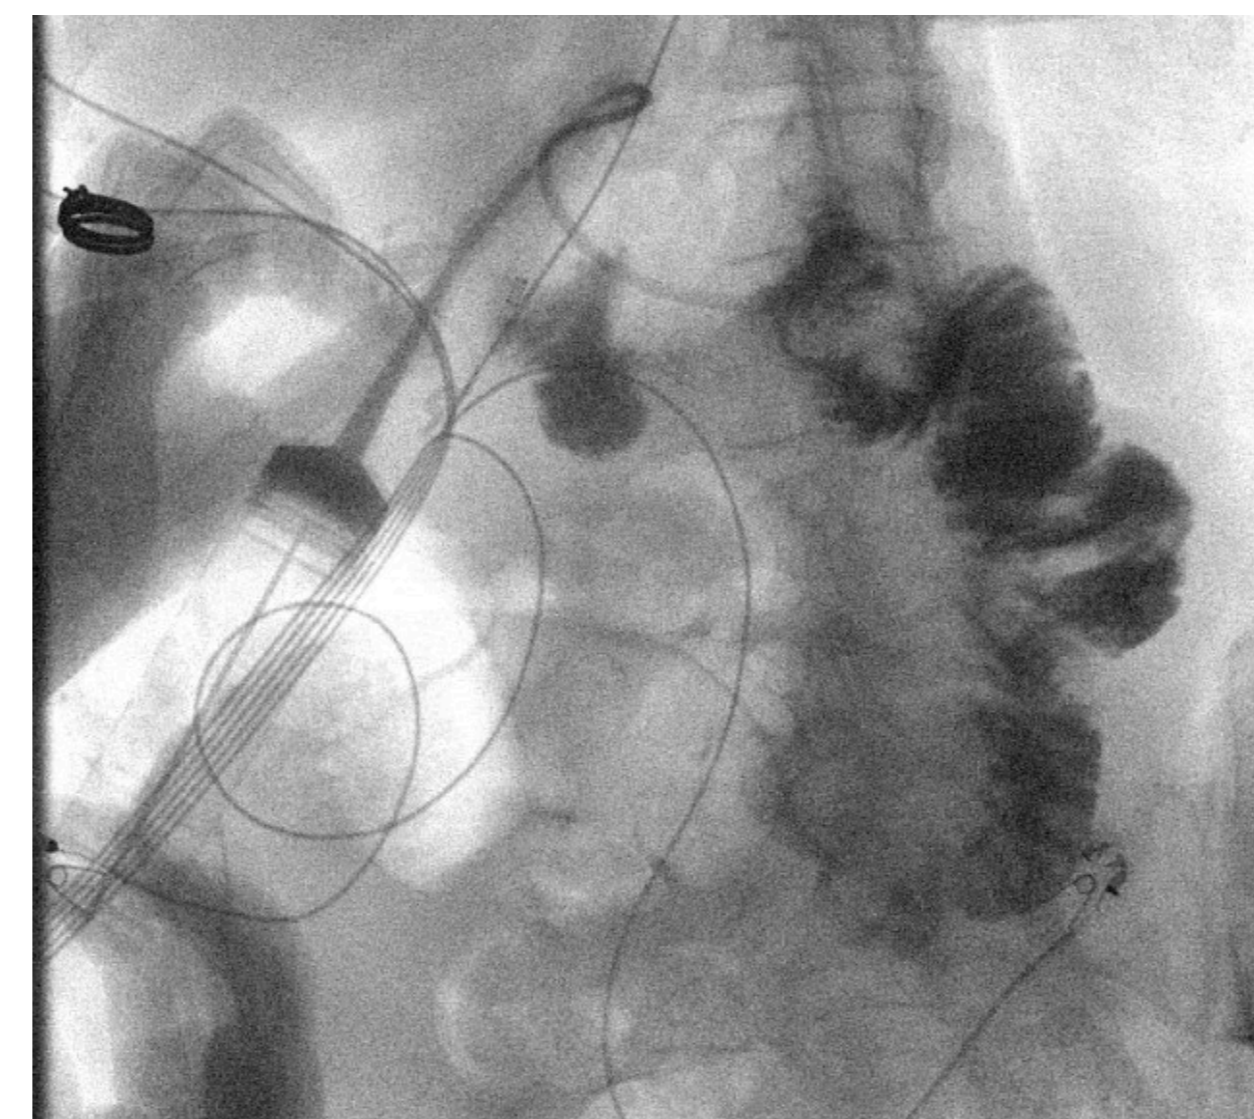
CT imaging showing the gastrostomy tube traversing the posterior aspect of the stomach and fistulized with jejunum with balloon inflated.
